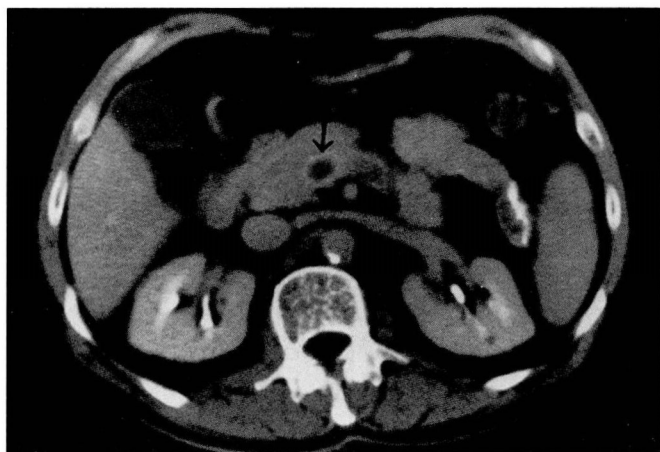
CT scan of abdomen at the level of the pancreas showing a low-attenuation area within the superior mesenteric vein consistent with thrombosis (arrow).
